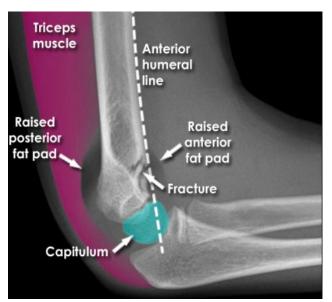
X-ray (lateral view), Anterior humeral line and fat pad sign.
